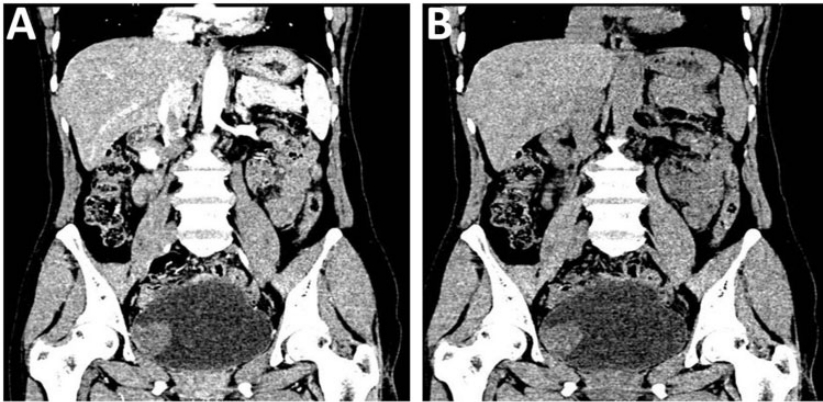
Enhanced coronal computed tomography results of bladder leiomyoma
